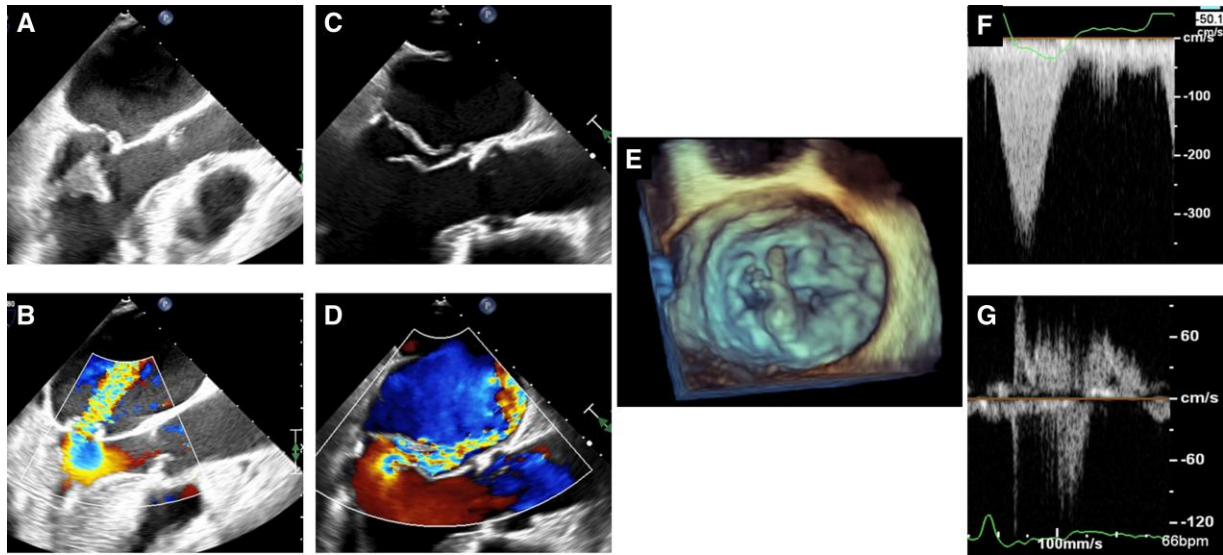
Echocardiographic findings in acute mitral regurgitation. Two-dimensional and colour Doppler imaging of papillary muscle rupture (A, B) and a flail posterior mitral valve leaflet (C, D) with associated three-dimensional imaging (E). Continuous-wave Doppler in acute mitral regurgitation (F) and pulsed-wave Doppler demonstrating systolic pulmonary vein reversal (G).
